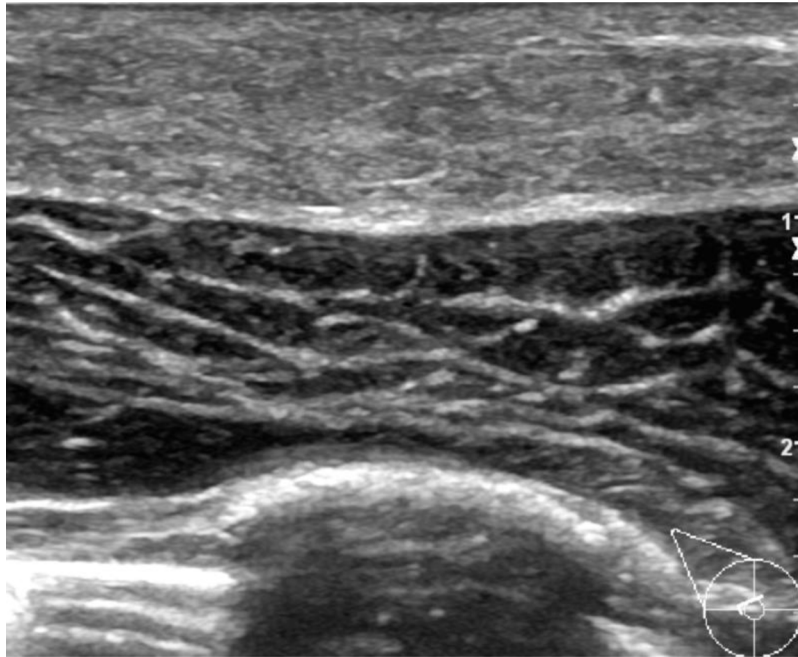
Ultrasound of the subareolar region of the right breast in the radial scanning plane, showing increased breast tissue most prominent in the 9:00-12:00 subareolar region.
